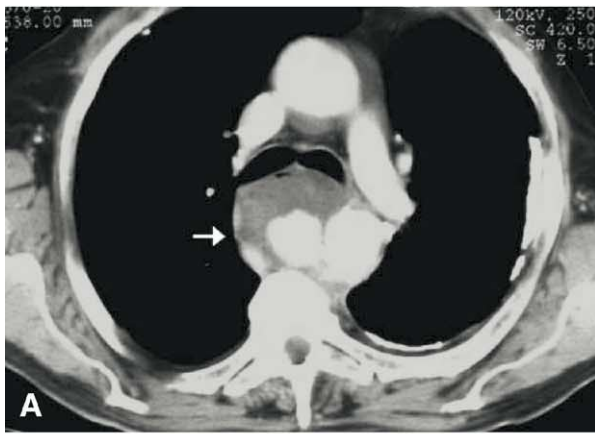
A, Enhanced chest computed tomographic scan demonstrates rupture of a descending thoracic aortic aneurysm with mediastinal hematoma. B, Caudal view showing blood clots in the esophagus due to an aorto-esophageal fistula. C, Bronchoscopic image showing a defect in the posterior aspect of the left main bronchus.
